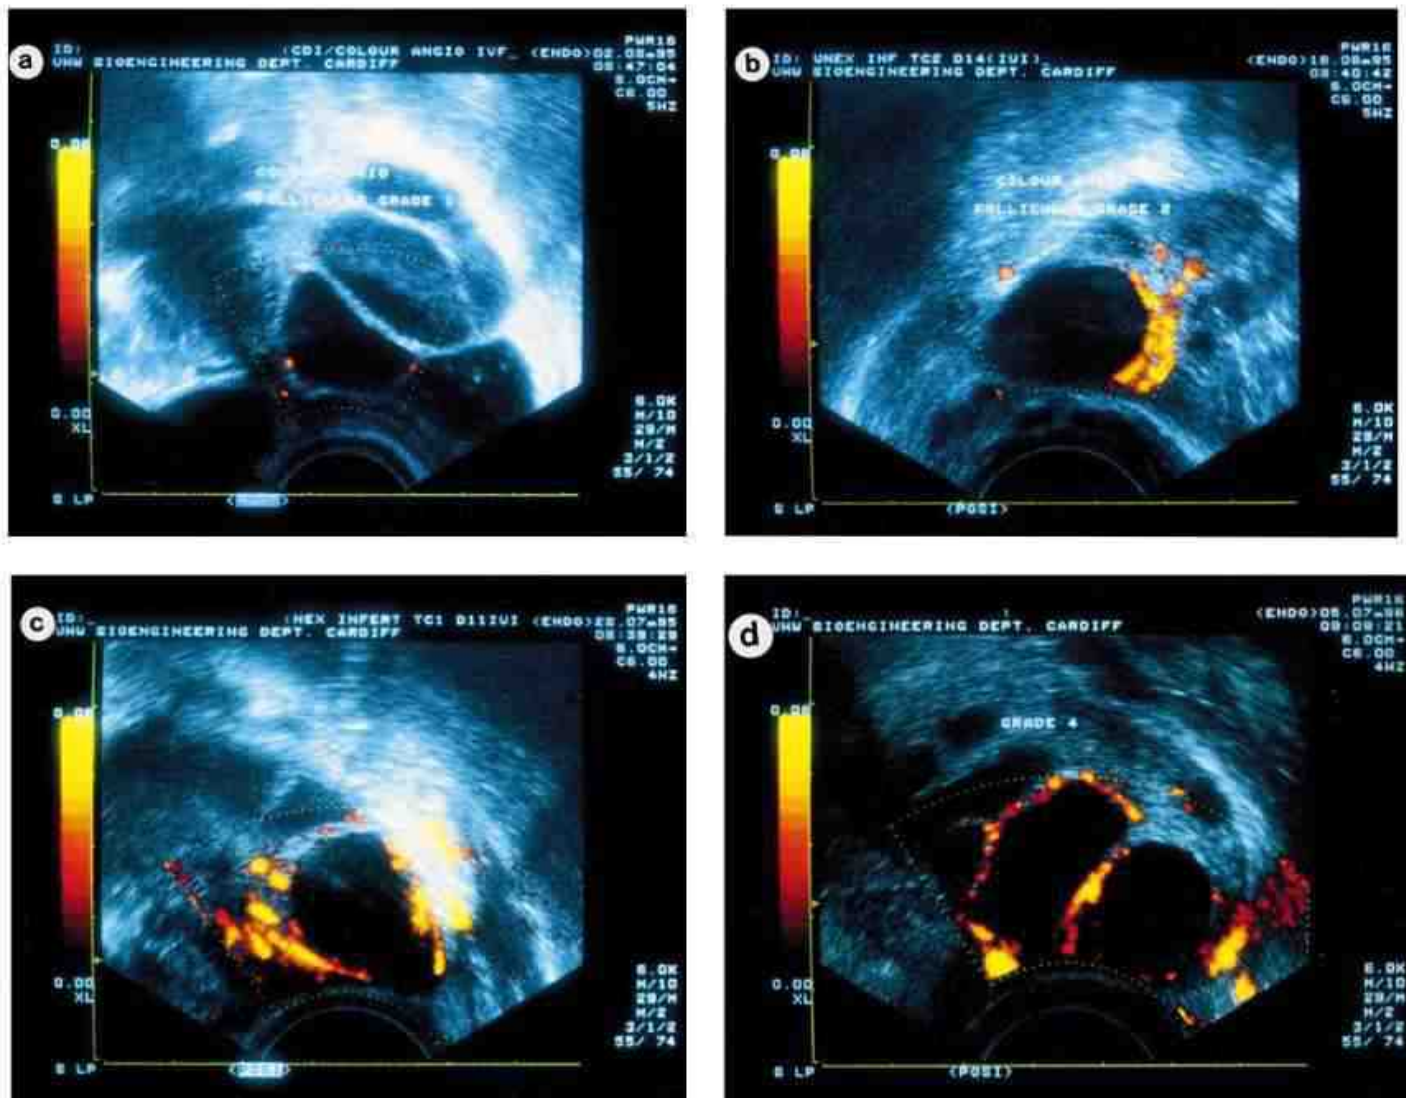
Power Doppler scans showing grading system used to assess follicular vascularity. (a) shows <25% circumferential flow (grade F1); (b) 26–50% flow (F2); (c) 51–75% flow and (d) >75% flow (F4).
